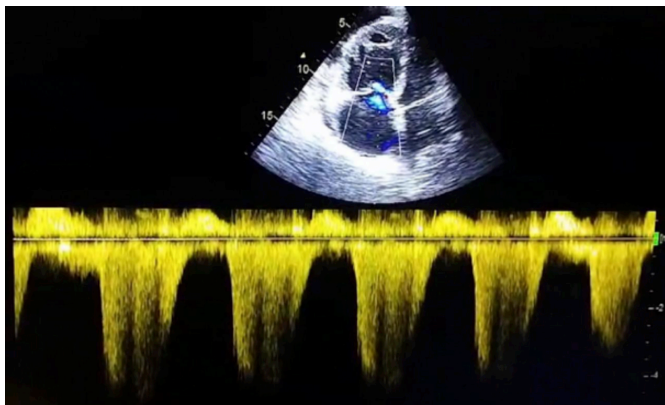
An echocardiogram showing dilated right atrium and ventricle with severe tricuspid regurgitation and a pulmonary artery systolic pressure (PASP) of 120 mmHg.
